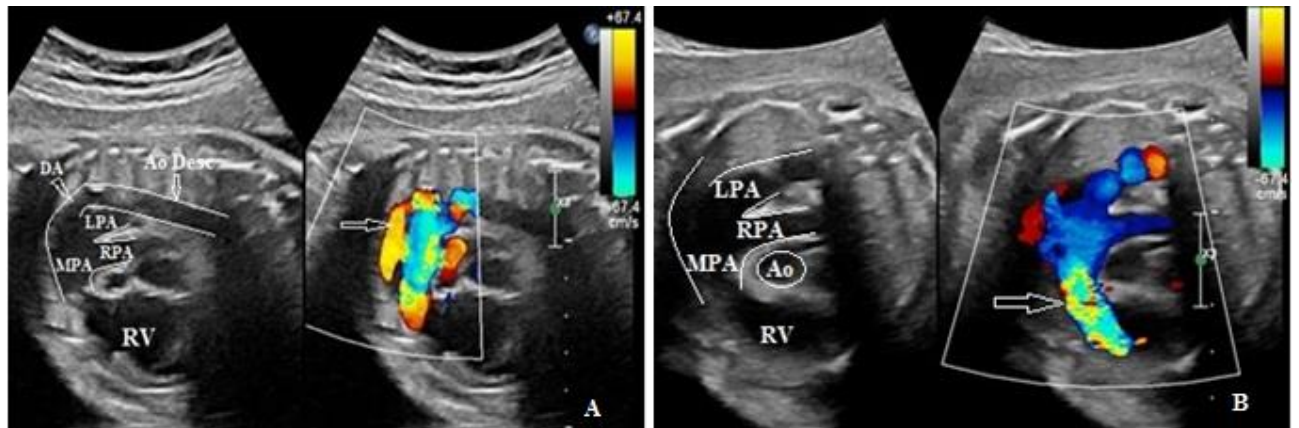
Fetus of 31 weeks of gestation with APVS/IVS. Ductal arch view with color Doppler demonstrates:
